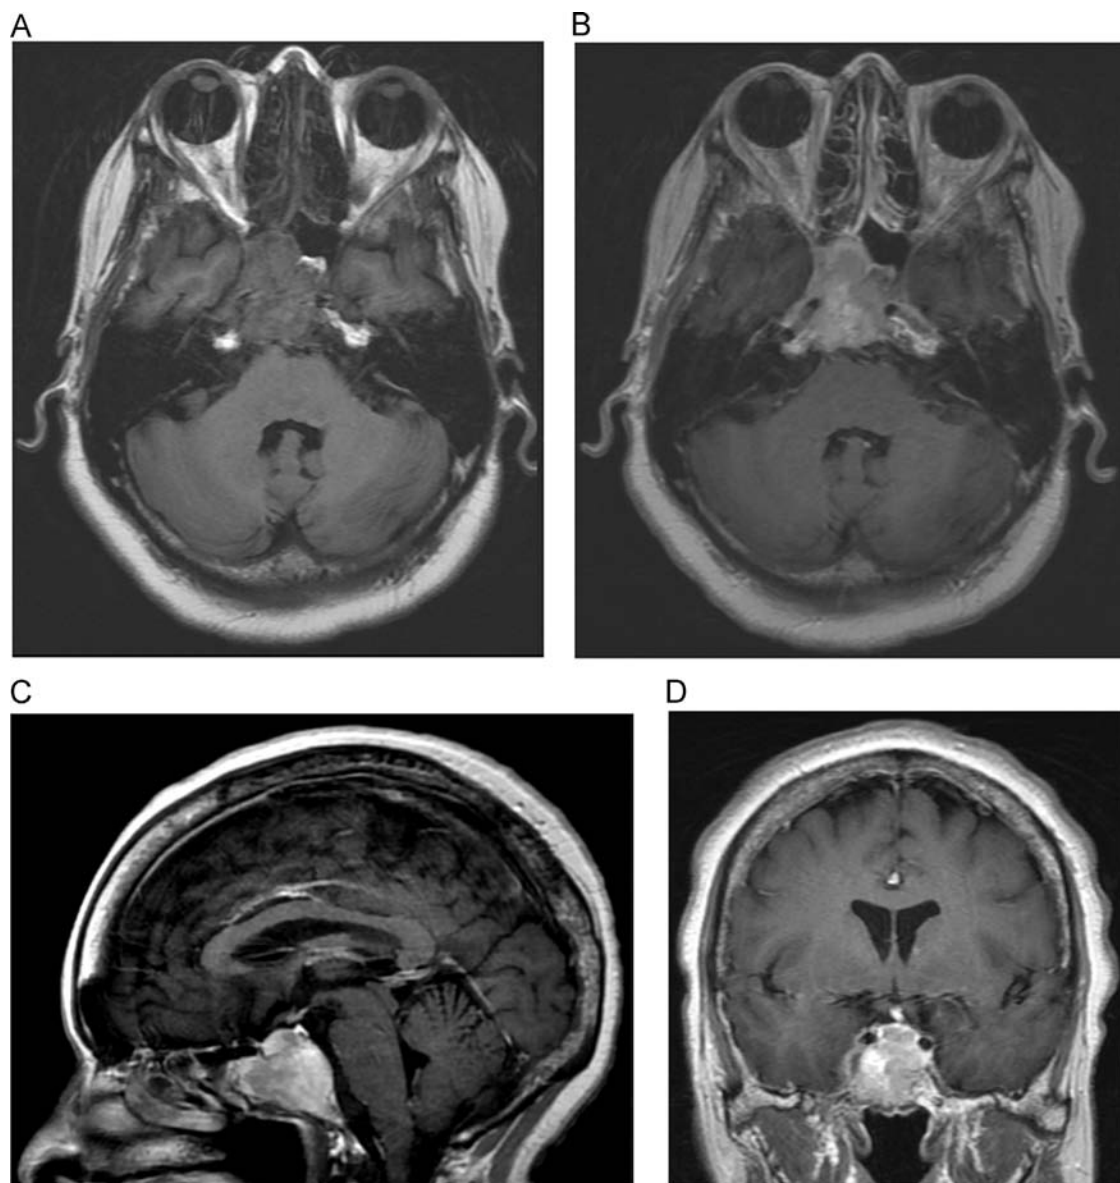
Magnetic resonance imaging of clival plasmacytoma, case 1. Images demonstrate the heterogeneously enhancing clival-based mass with extension into the right cavernous sinus. T1 axial precontrast (A) and postcontrast (B), sagittal postcontrast (C), and coronal postcontrast (D).
